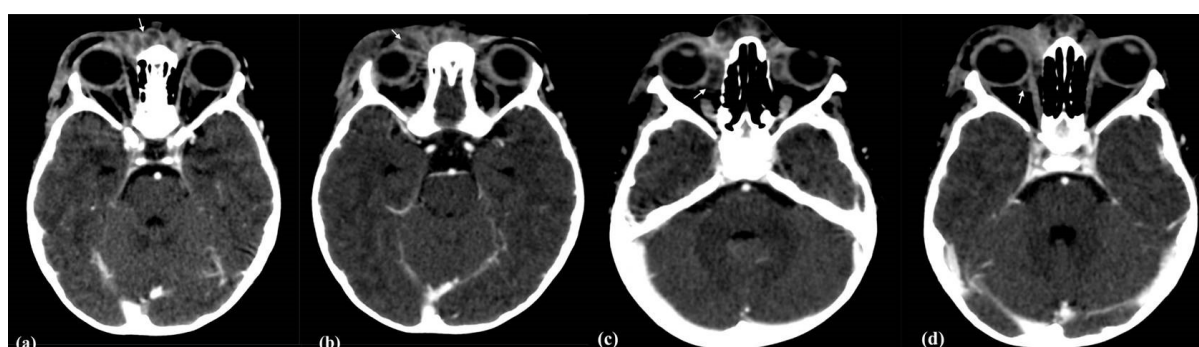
Contrast enhanced computed tomography (CT) scan of brain, paranasal sinuses and orbit revealed rim enhancing hypodense lesions (white arrow): (a) at nasal, (b) right preseptal, (c) extraconal along the medial aspect of the right medial rectus muscle and (d) intraconal space of the right orbit. (Click image to enlarge.)
